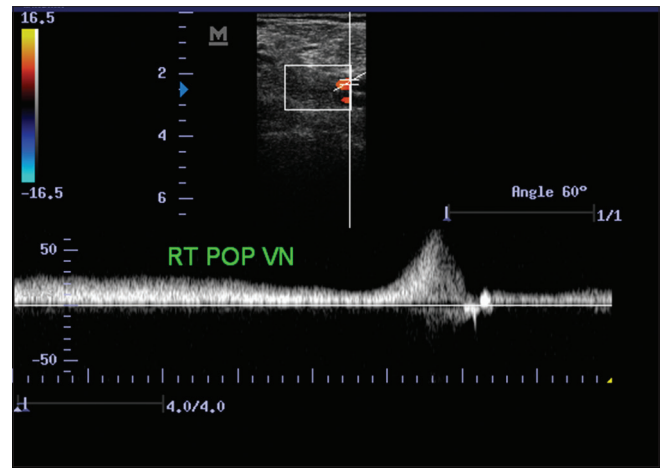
A spectral Doppler sonogram of the right popliteal vein showing normal respiratory variation and positive venous augmentation response
